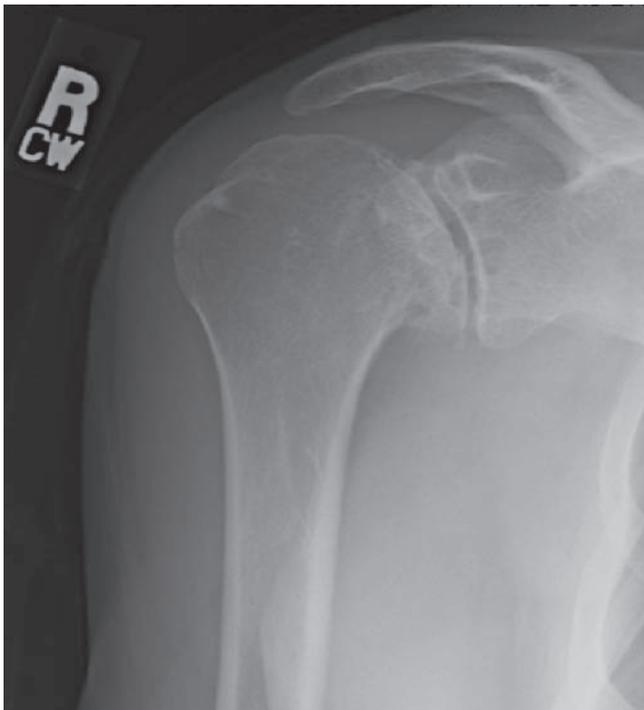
Antero-posterior radiograph of a 44-year old male 18 years following an open Bankart procedure for recurrent anterior shoulder instability.
